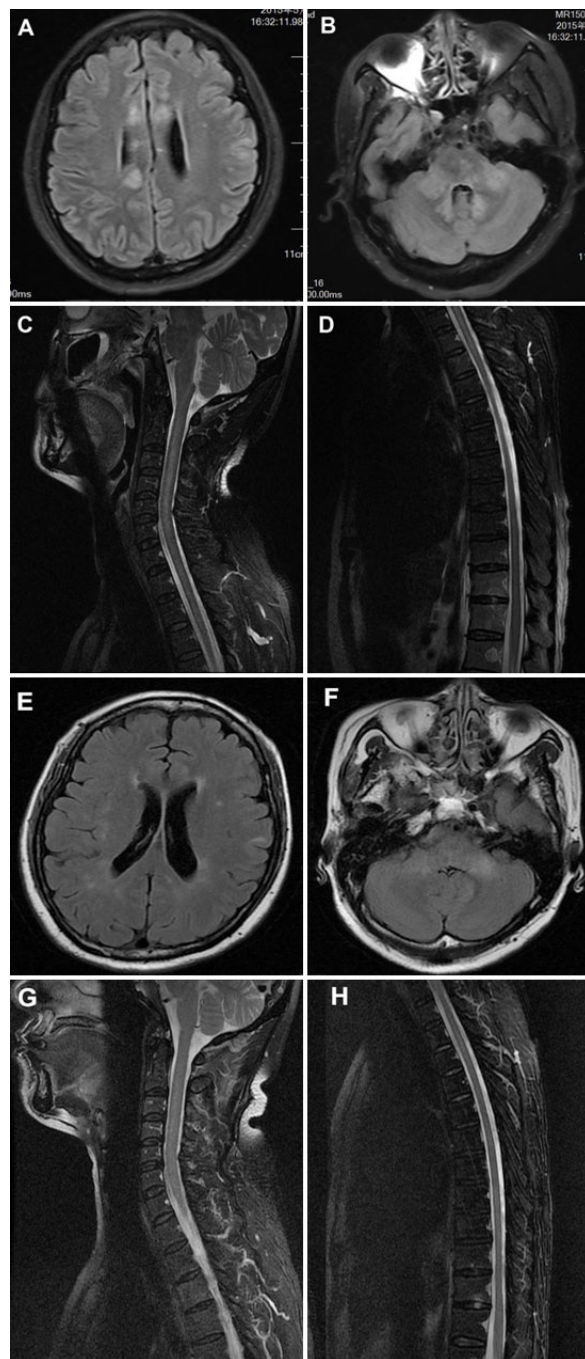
Magnetic resonance imaging (T2 flair) (A-D) disseminated demyelination lesions intracranial and spinal cord within 1.5 months after onset; (E-H) within 3 months after onset (in which she was treated with high dose intravenous methylprednisolone)
